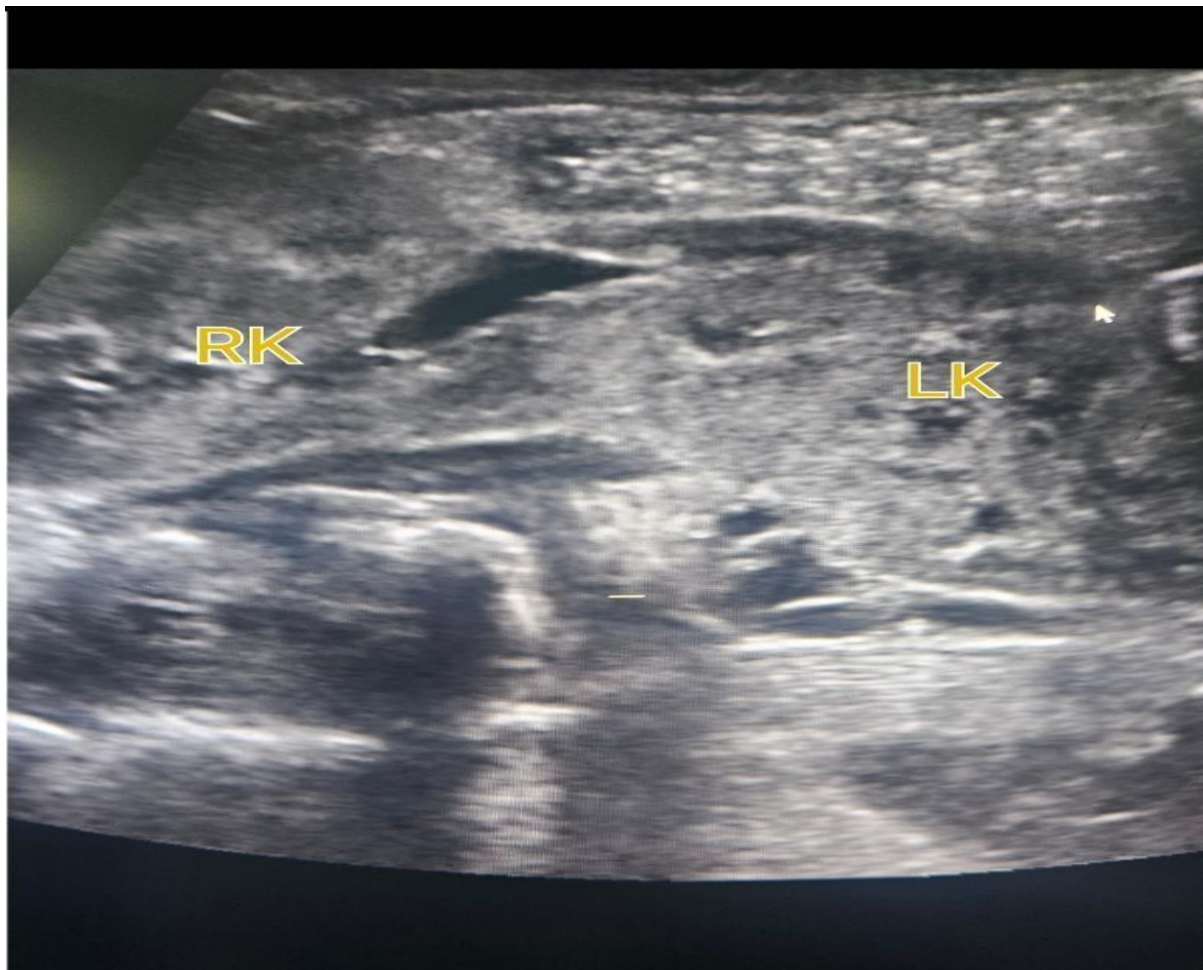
Case report, Image Ultrasonography, Renal system of the newborn: Fused right ectopic kidney
